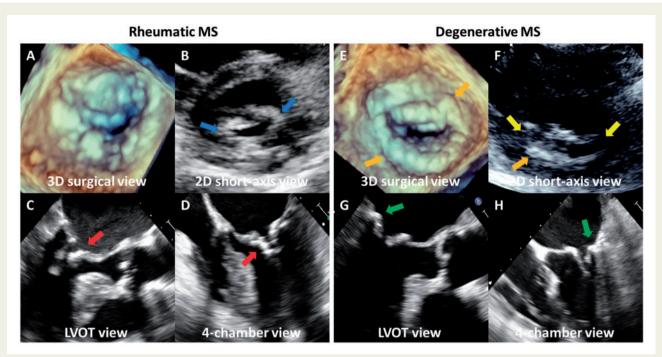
Echocardiographic still frames of patients with degenerative and rheumatic mitral stenosis. Rheumatic mitral stenosis is characterized by commissural fusion, chordal shortening and fusion, and leaflet thickening or restricted leaflet motion due to extensive calcification (A–D). Degenerative mitral stenosis is characterized by annular calcification in combination with leaflet thickening and/or calcification, and restriction of leaflet motion without commissural fusion (E–H). Blue arrows indicate commissural fusion. Red arrows indicate leaflet thickening due to extensive calcification. Orange arrows indicate mitral annular calcification. Yellow arrows indicate absence of commissural fusion. Green arrows indicate annular calcification in combination with leaflet calcification.
